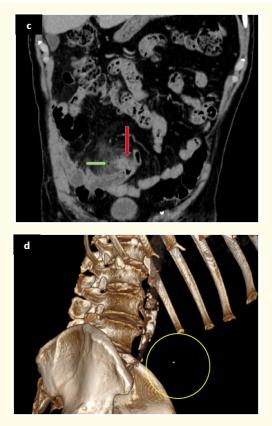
Abdominal-pelvic CT after PDC injection: a: axial, b: sagittal, c: coronal plans. Meckel diverticulum implanted at an intestinal loop with narrow diverticular collar (red arrow), Densification of diverticular peri fat and the presence of some pneumoperitoneum bubbles (green arrow). d: Reconstruction in technical volume rendering mode (VRT): the foreign object included in the Meckel diverticule visible only on the VRT reconstruction (Yellow circle).
